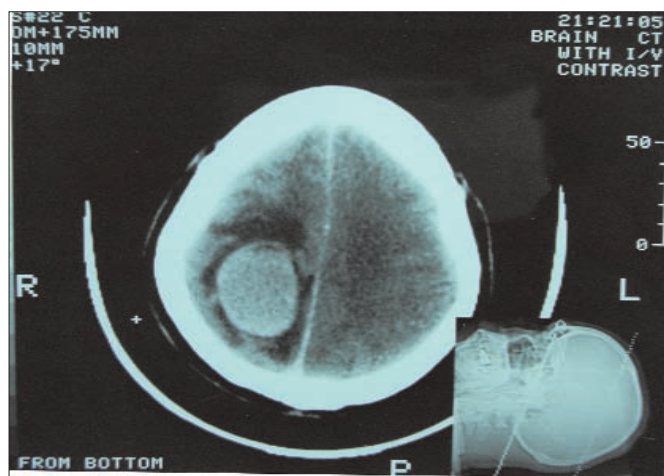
CT scan done on 27th December 2001 showing SOL in right parieto-temporal region of brain.
